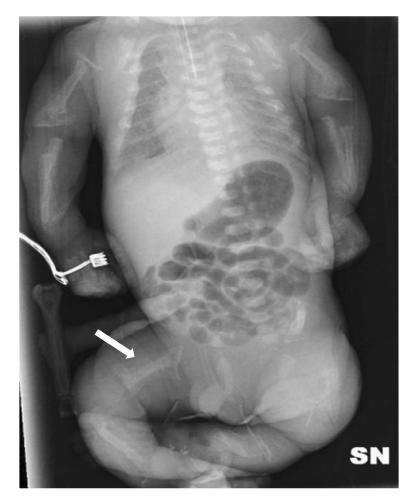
Total body X-ray of the patient. The radiograph shows extensive cloaking of the right femur (white arrow); the figure also shows common skeletal signs of MLII, such as, severe generalized osteopenia, talocalcaneus stippling, irregular demineralization of metaphyses of long bones and cupped physeal-metaphyseal junctions resembling those of rickets, bowing of long bones, vertebral body rounding, altered hip morphology, including acetabular dysplasia, femoral head abnormalities, and an altered acetabulum-femoral head relationship.
